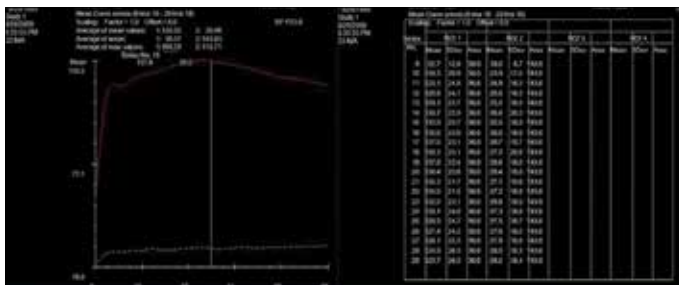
Dynamic contrast enhanced MRI in a 14-year-old female. Time- intensity curve obtained from the ROI placed over the MR renogram images in patient with normal right kidney and left PUJO with gross hydronephrosis
